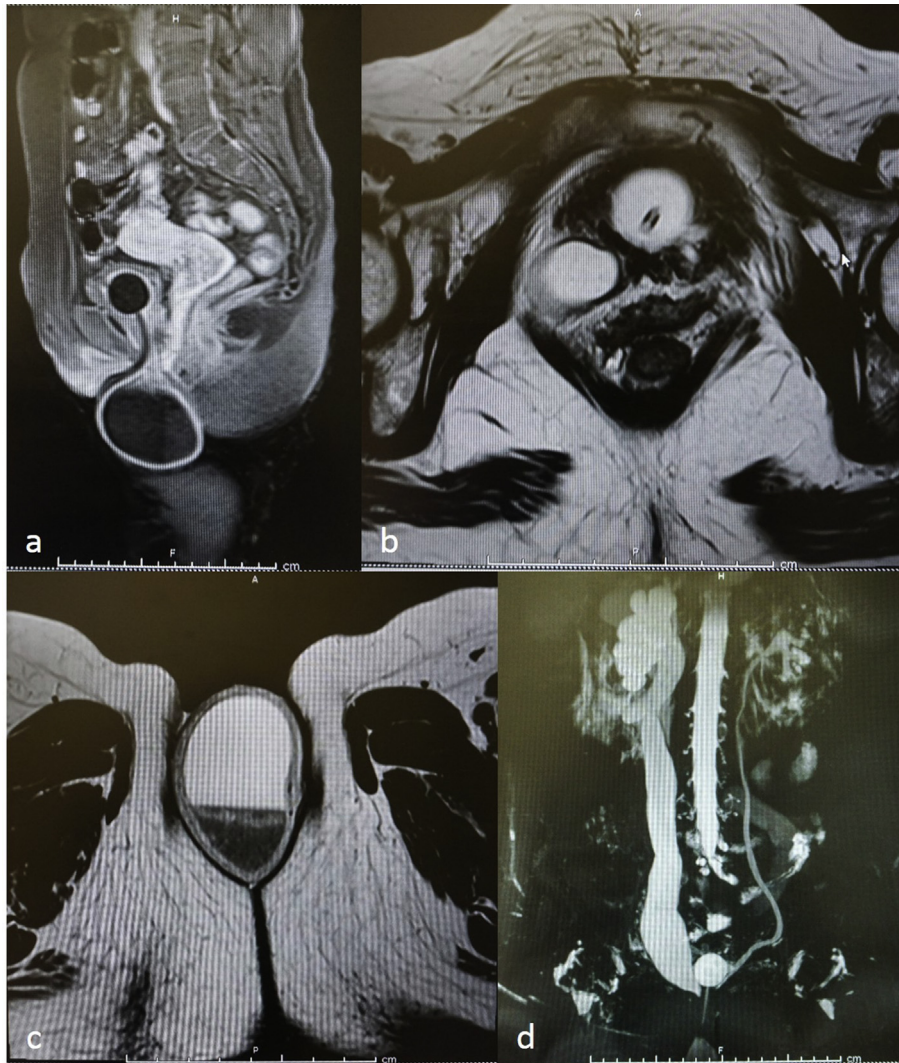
MRI of pelvis demonstrated the mass originated from urinary tract system and its content showed fluid level. a, T1-weighted MRI, sagittal plane, b, T2-weighted MRI, axial plane at the bladder level, c, T2-weighted MRI axial plane at the mass, and d, coronal reconstruction of urinary tract.
